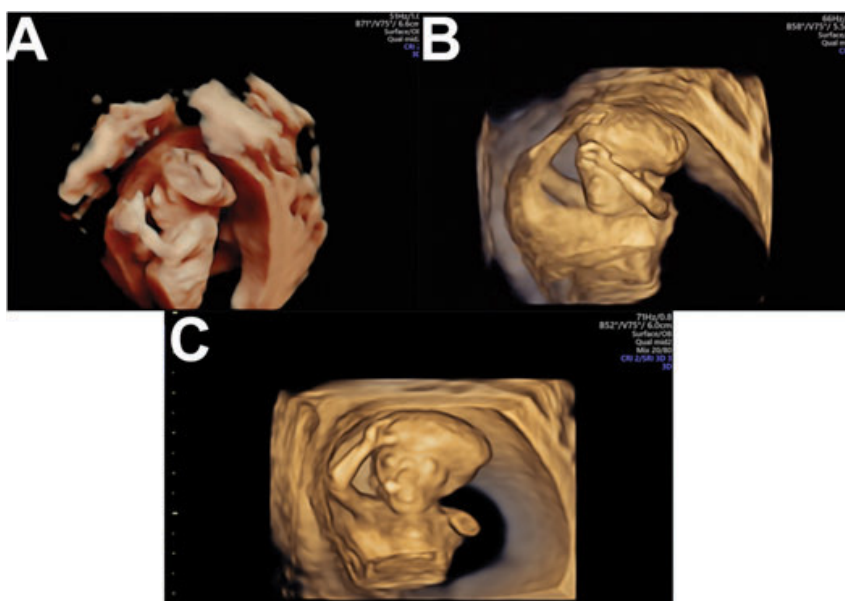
Three-dimensional ultrasound images of the fetus at 13 weeks showing the abnormal morphology of the cephalic segment, with the appearance of the “beret sign”. This examination can help to exclude differential diagnoses such as holoprosencephaly and encephalocele.
